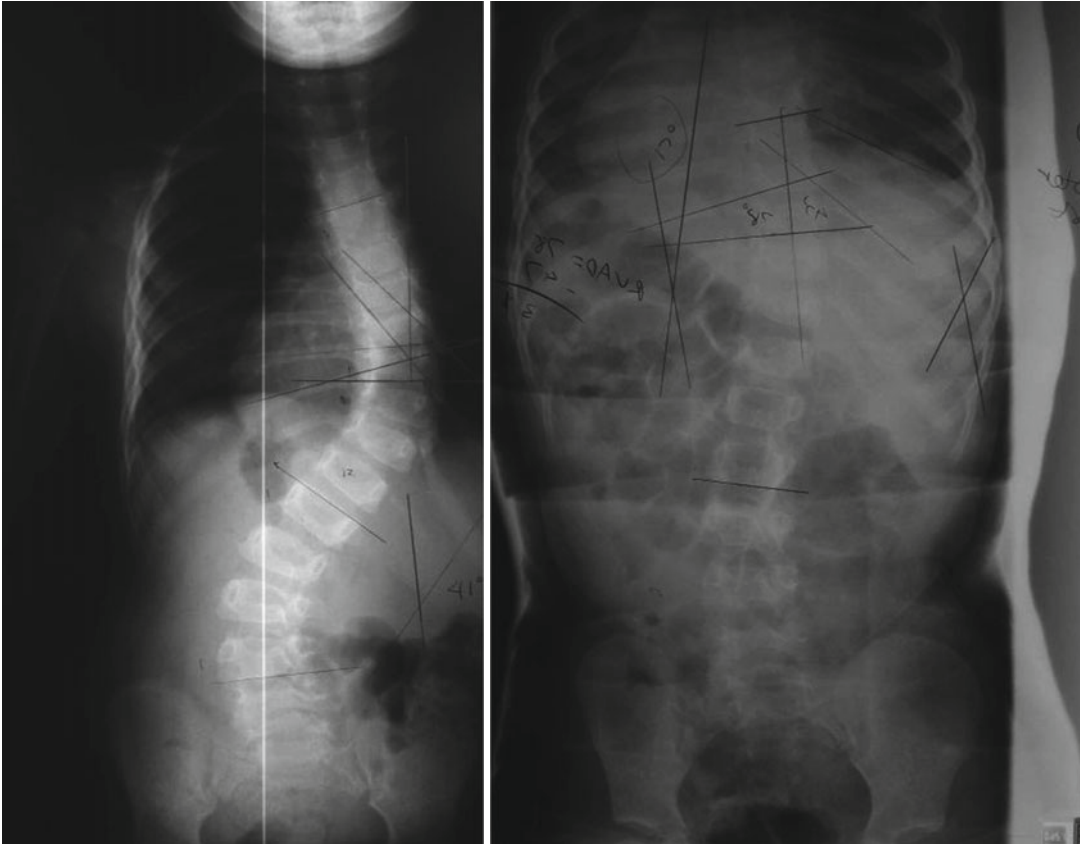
Radiographs comparing the curve before and in the cast. A proper cast does not push the ribs into the spine
